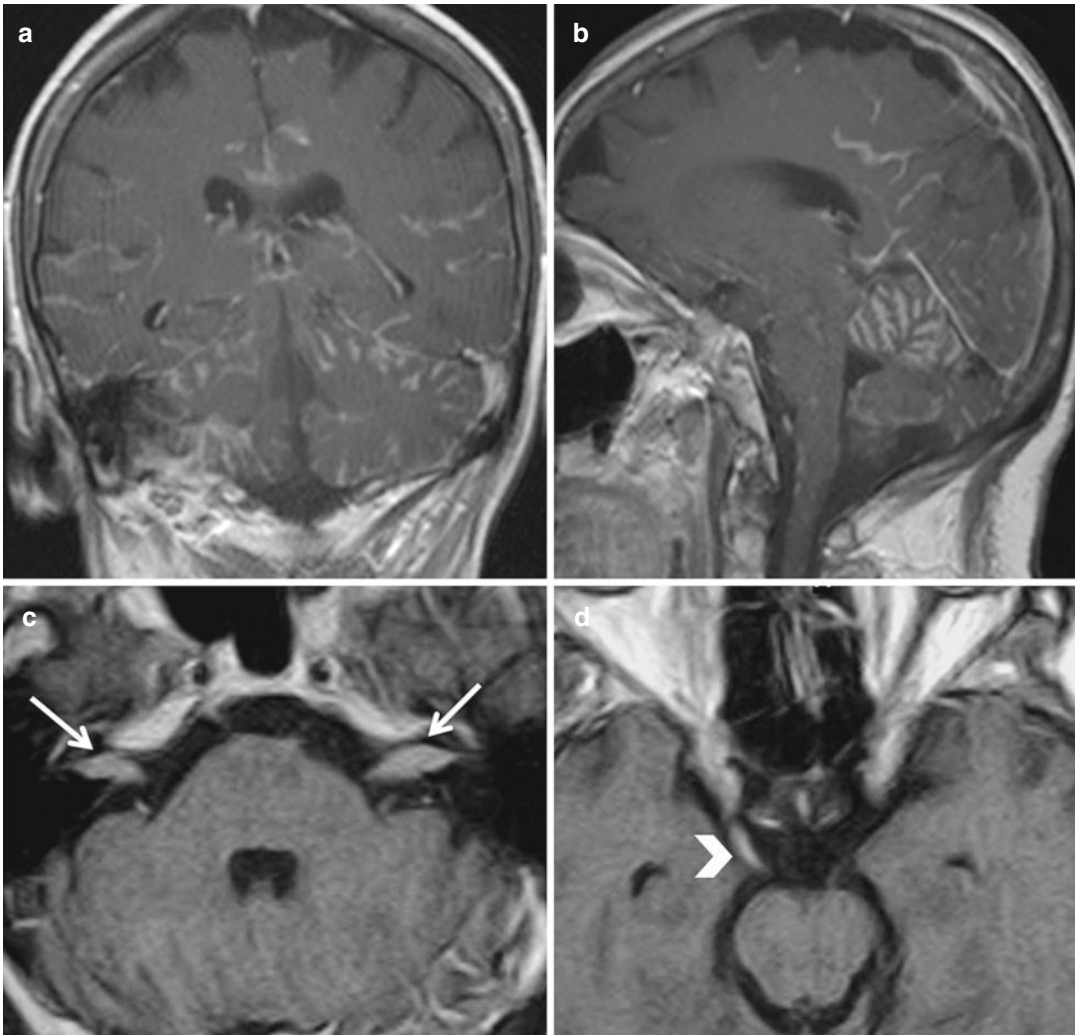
Leptomeningeal carcinomatosis. T1-weighted images post contrast medium. In (a, b) diffuse leptomeningeal enhancement is seen, mostly along cerebellar folia.
